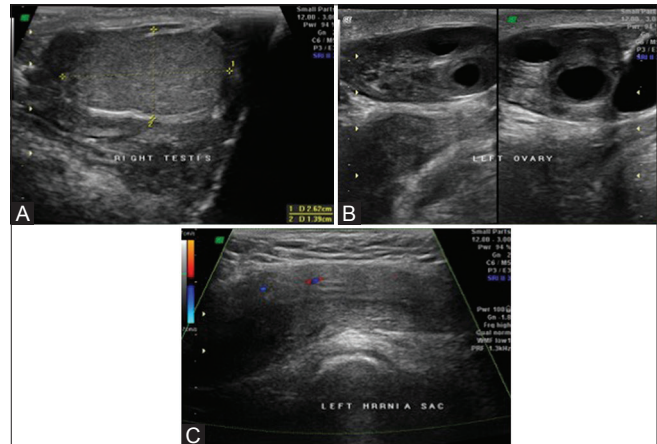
(A-C): (A) Grey scale ultrasound image shows small testis in the right scrotal sac. (B) Grey scale ultrasound image shows normal sized ovary with follicles in the left scrotal sac. (C) Grey scale ultrasound image shows left inguinal hernia sac with non-functioning uterus within it
